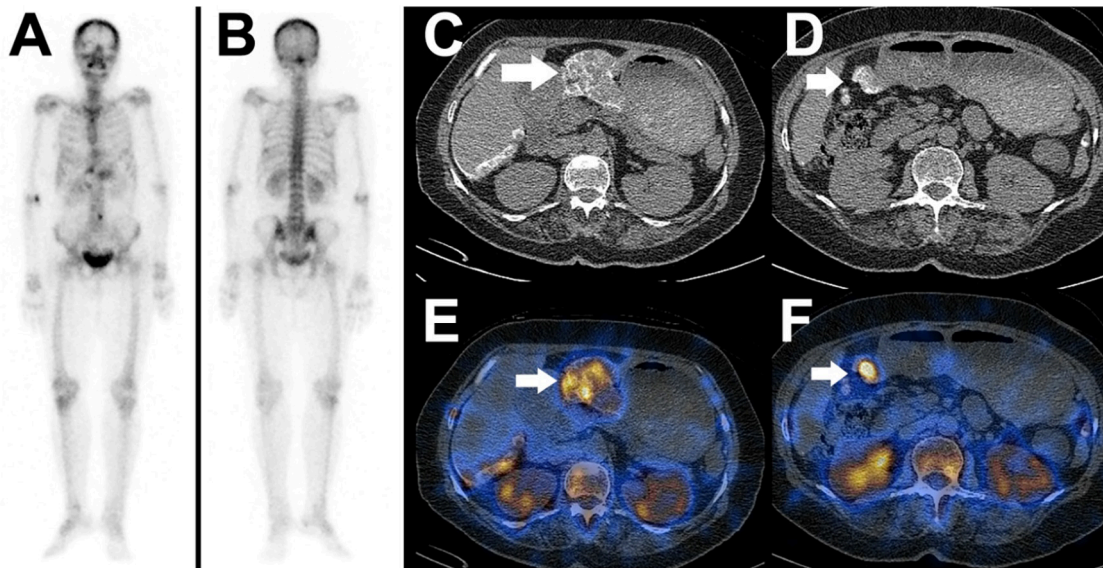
Ovarian cancer is the seventh most common cancer worldwide in women (1). The mortality rate is high, attributable to diagnosis at an advanced stage, which is often known to be a “silent killer” (2,3). Tc-99m-methylene diphosphonate (MDP) is a bone-seeking radiopharmaceutical used to rule out bone metastases. On bone scintigraphy, the uptake can be seen at sites other than the bone in a varying number of benign and malignant conditions. In this case, a woman in her sixties had stage III papillary serous adenocarcinoma (PSAC) ovary diagnosed almost 3 years ago (in 2020). She received three cycles of neoadjuvant chemotherapy and underwent total abdominal hysterectomy and bilateral salpingo-oophorectomy, infraepiploic omentectomy, left paracolic peritoneum, and pelvic peritoneum removal. Thereafter, the patient was asymptomatic and was followed up. A follow-up contrast-enhanced computed tomography (CT) scan of the abdomen showed few hypodense lesions in the liver and multiple soft tissue lesions indenting the liver surface in the peritoneum and abdominal wall with few small bilateral lung nodules, which were suspicious for widespread metastases. Therefore, the patient received 9 cycles of adjuvant chemotherapy with paclitaxel and bevacizumab for 6 months. The patient presented with lower backache during the course of chemotherapy. Tc-99m-MDP bone scan was performed to rule out any bone metastases. (A, B): Anterior and posterior planar bone scan images show increased tracer uptake in the lower thoracic and lumbar vertebrae region, although the uptake in the lower thoracic vertebrae region is not limited to the bones. To rule out this dilemma, single-photon emission computed tomography/CT (SPECT/CT) of the abdomen and pelvis was performed. (C-F): axial CT and fused SPECT/CT images of the abdomen show tracer uptake in the calcified deposits along the surface of the liver (peritoneal) and other peritoneal deposits (arrows), suggestive of peritoneal metastatic disease ruling out bone metastases.
